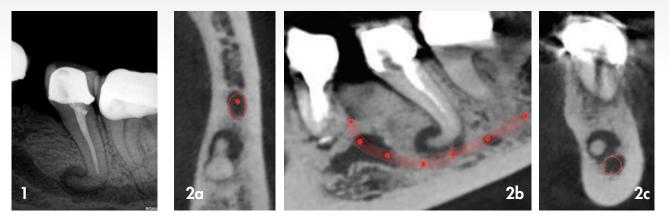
Preoperative periapical radiograph of a mandibular, second premolar with poorly done root canal treatment. Note the periapical pathology around the apical part of the root.
